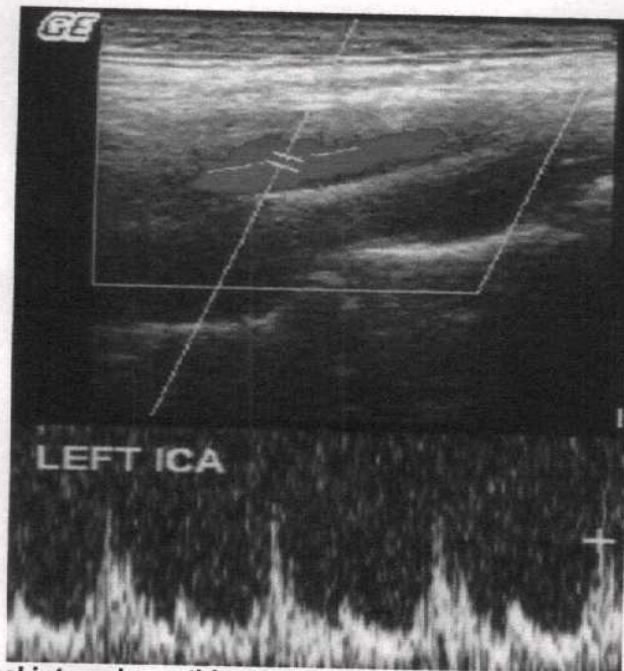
D): Normal internal carotid artery Doppler waveform showing relatively broad peaks and large amount of flow throughout diastole.
